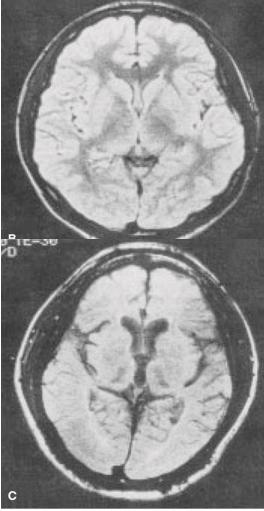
(A) Inhalant and cocaine abusers with subcortical abnormalities, by brain region affected. (B and C) Brain damage in a toluene abuser. (A) Magnetic resonance imaging (MRI) scans of chronic inhalant abusers and chronic cocaine abusers showed more frequent occurrence of abnormalities in the basal ganglia, cerebellum, pons, and thalamus for those who abused solvents. (Methias, 2002.) MRI shows marked atrophy (shrinkage) of brain tissue in a toluene abuser (C) compared with a nonabusing individual (B). Note the smaller size and the larger empty (dark) space within the toluene abuser's brain. The white outer circle in each image is the skull. (Available electronically at http://www.drugabuse.gov/PDF/RRInhalants.pdf.) (Courtesy of Neil Rosenberg, MD, as published in NIDA Research Report Series, March 2012.)
